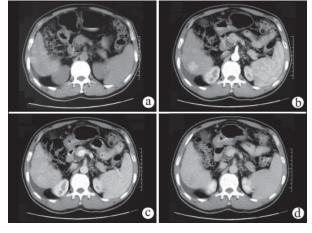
Multiphasic enhanced CT of a HCC associated with cirrhosis. (a) Precontrast CT showed a hypoattenuation nodule; while the nodular contour, parenchymal heterogeneity in attenuation, ascites and splenomegaly were indicative of cirrhosis. (b) In arterial phase, the nodule showed unequivocal hyperenhancement which had much higher enhancement than the adjacent background and precontrast baseline. (c) In portal venous phase, the nodule showed less enhancement but still higher than the background liver. (d) In delayed phase, the nodule demonstrated unequivocal washout which showed lower attenuation than the adjacent parenchyma.
